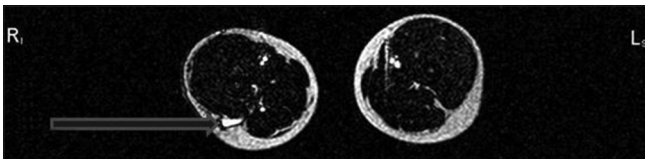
Magnetic resonance imaging angiography showing dilated superficial veins on the right side
